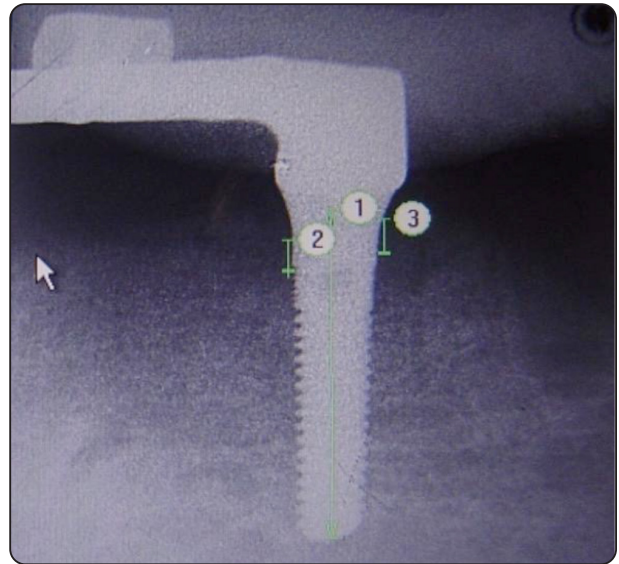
periapical radiograph for measuring the crestal bone loss.
